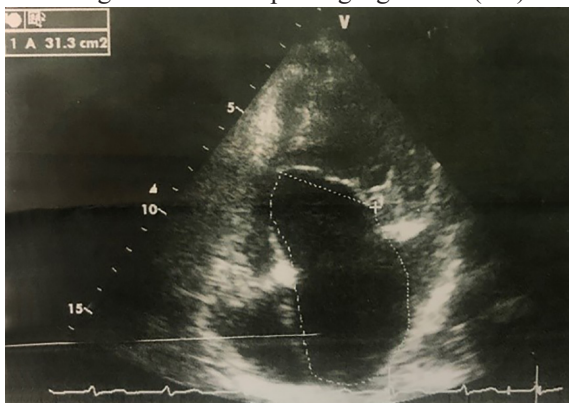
Two-dimensional echocardiography apical four chamber view revealed Ebstein anomaly in tricuspid valve in congenitally corrected transposition of a great vessel
